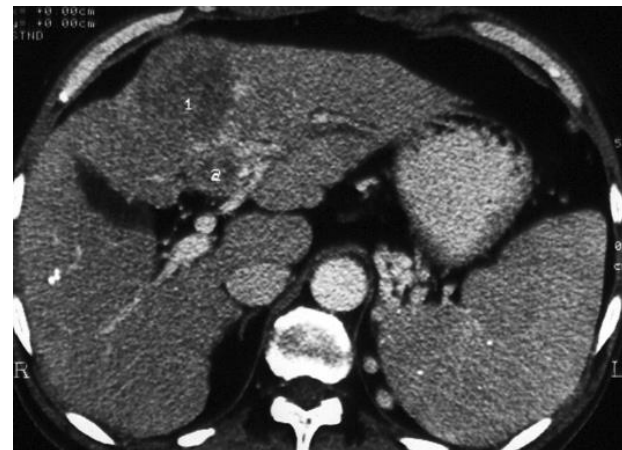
CT of the abdomen – liver metastases: characterization of the relationship with vascular structures
